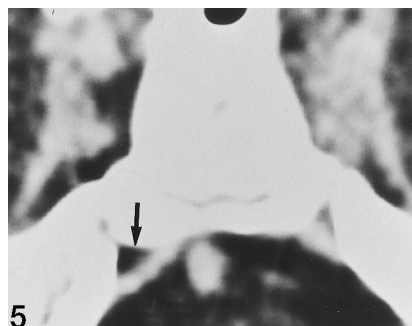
Axial contrast-enhanced CT scan in 9-year-old boy with bilateral cavernous sinus thrombosis due to acute right-sided mastoiditis. Confluent areas of thrombus formation are present within the cavernous sinus bilaterally, more pronounced on the right. Thrombosis is present in the right inferior petrosal sinus (straight arrow) while the left inferior petrosal sinus is spared.
